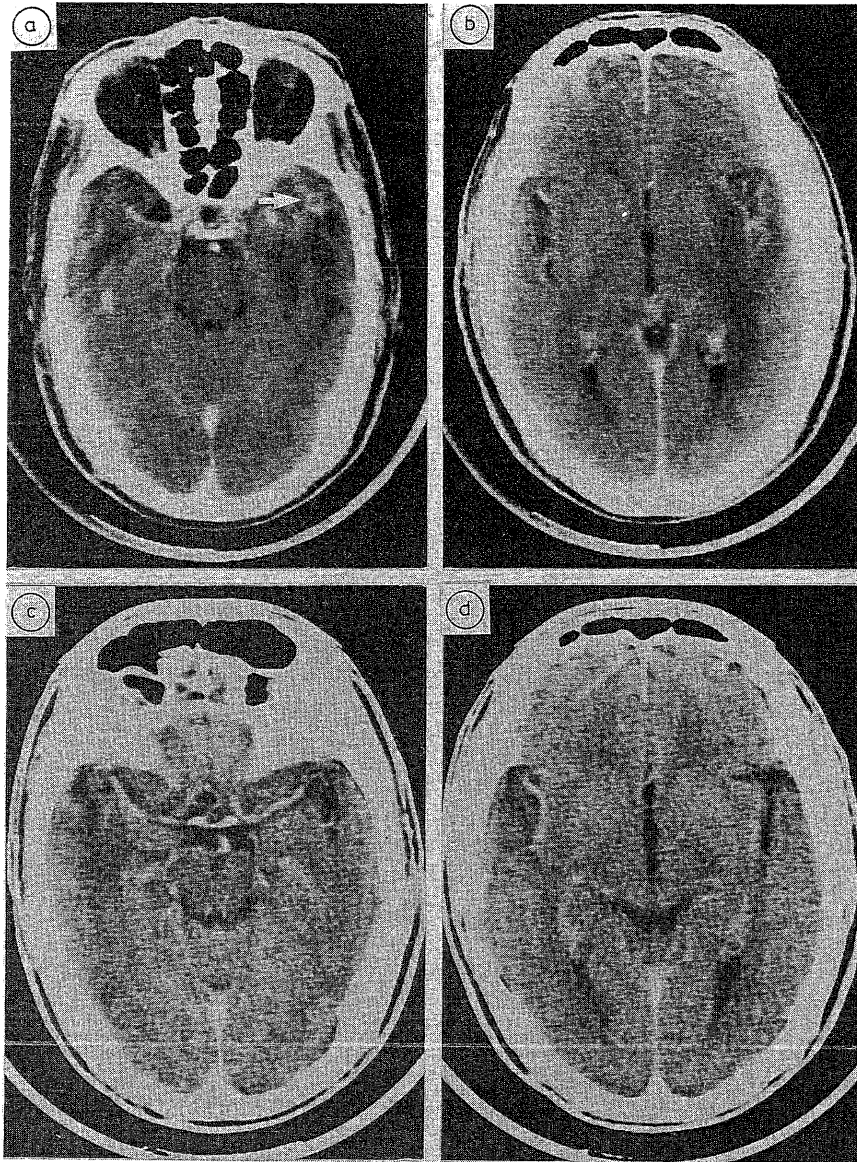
Patient 1. (A, B) Initial CT scan showing a left temporal hypodense area with minimal mass effect. Patchy contrast enhancement with suggestion of a ring pattern (arrow) was present. A small area of decreased attenuation was also present in the right temporal tip without any mass effect or enhancement. (C, D) Follow-up CT scan 17 months later showing almost complete resolution of the left temporal hypodensity with loss of mass effect and contrast enhancement. The right temporal hypodensity had remained relatively unchanged.
